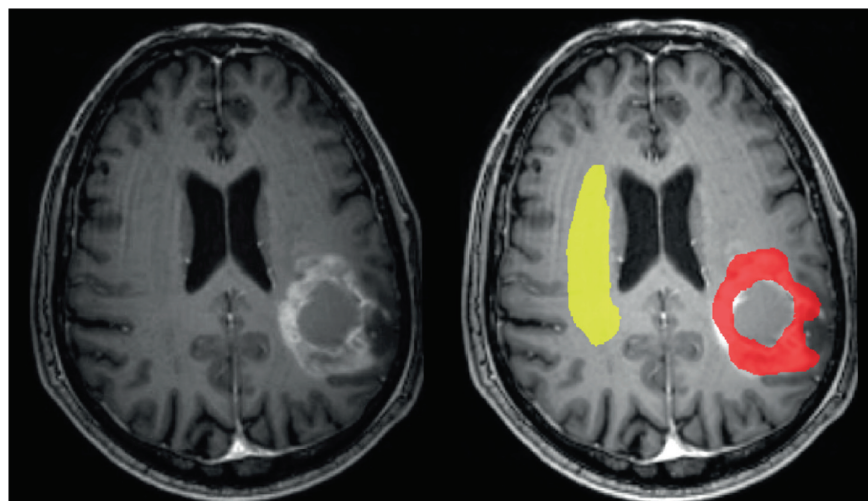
Example showing delineation of regions of interest on T1w-contrast enhanced MRI. Yellow mask on rightmost image: normal appearing white matter. Red mask: tumor. Note that the central tumor cavity was not included in the ROI.
